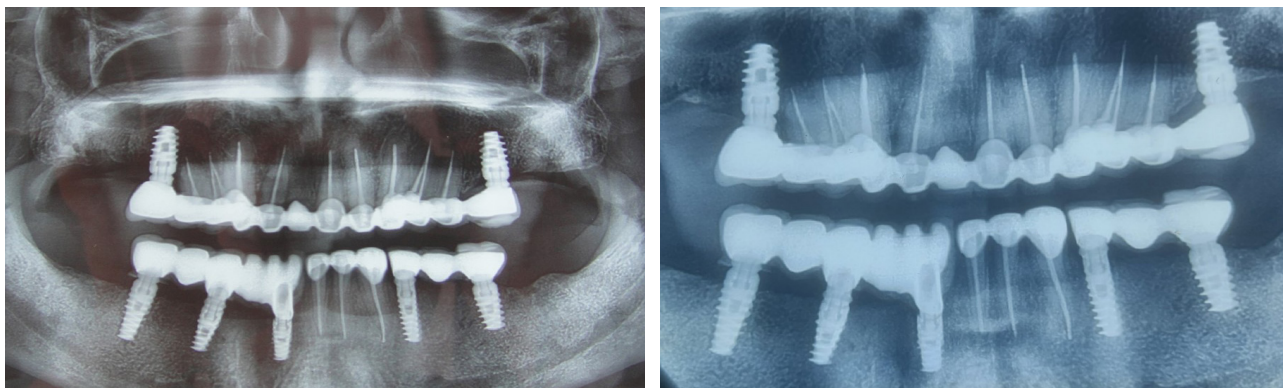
A) Post-operative radiographic view after one year of full mouth rehabilitation. B) Post-operative radiographic view after six years of full mouth rehabilitation.
